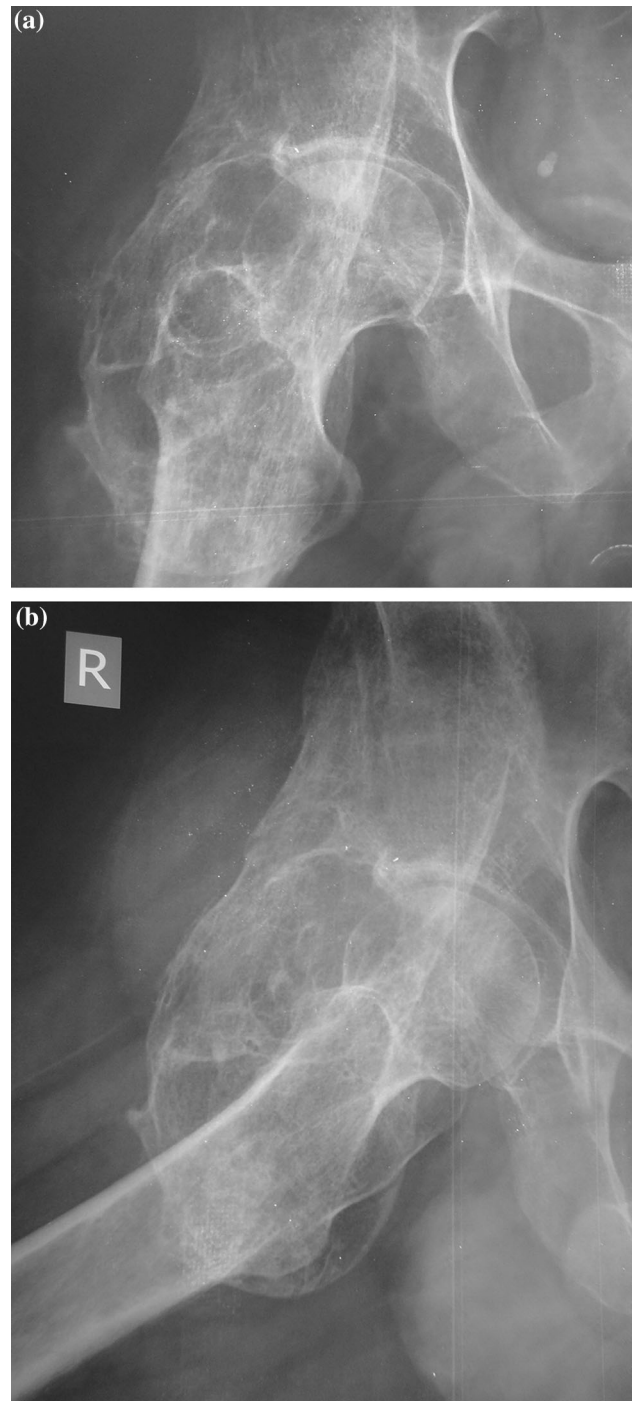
a, b Preoperative X-rays of a 30-year-old male with Brooker IV HO after traumatic brain injury
